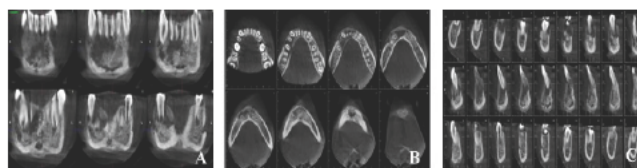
CBCT images. A: coronal view shows the cotton wool appearance of the mandible. B: Axial view demonstrated expansion of buccal and lingual plate without expansion. C: Cross-sectional view.
